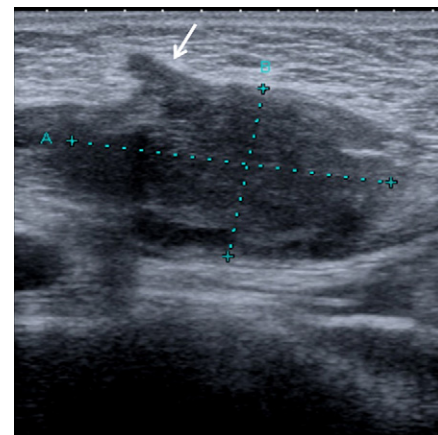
A 53-year-old woman who suffered from a painful nodule on the medial plantar surface of the foot. Sonography shows a nodule (between the dotted lines) attached to the plantar aponeurosis (orange arrow): plantar fibromatosis or Ledderhose’s disease.
